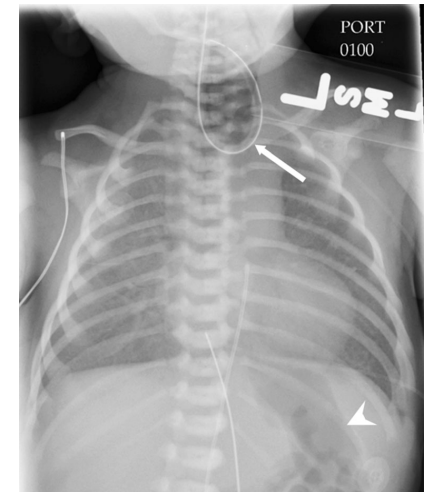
Tetralogy of Fallot and esophageal atresia/tracheoesophageal fistula. Anteroposterior chest radiograph in a newborn boy shows that the heart has a boot-shaped contour with an upturned apex compatible with a diagnosis of tetralogy of Fallot. A nasogastric tube is coiled in the upper esophageal pouch (*arrow*), consistent with esophageal atresia. The presence of bowel gas (*arrowhead*) in the upper abdomen confirms the presence of a tracheoesophageal fistula. There are also 13 pairs of ribs
